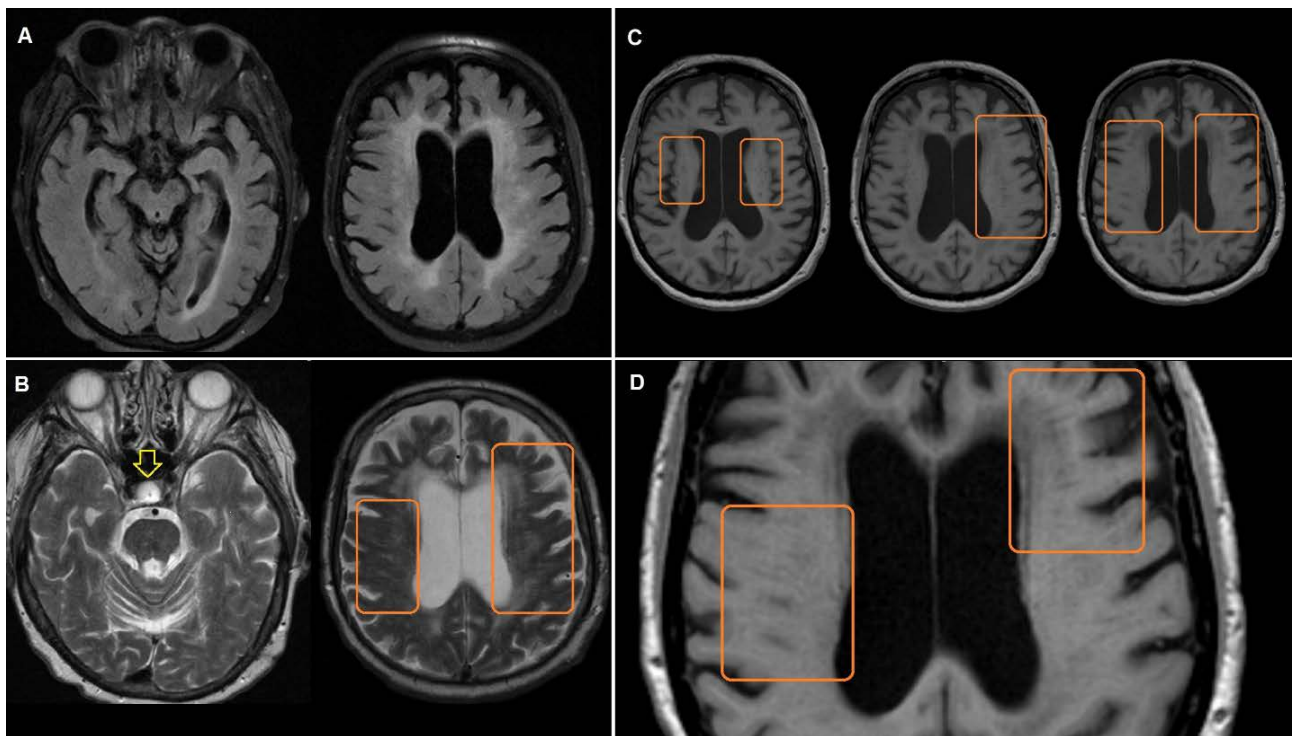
Axial FLAIR, T2-w, and T1-w Magnetic Resonance Images of the patient. Magnetic images using a 3-Tesla scanner, which is more sensitive to brain water content, show periventricular white matter disease on FLAIR (A), and a “Comb sign” on T2-(B) and T1-weighted (C) images, representing prominent tubular Virchow-Robin perivascular spaces of various diameters that are more anterior than posterior. One of the T1-weighted images is magnified (D) for better viewing of the tubular perivascular spaces, which disproportionately affect the anterior subcortical region. The T2-weighted sequences also reveal an empty sella (yellow arrow), which can at times be associated with pseudotumor cerebri. This patient, however, had normal CSF pressures.
